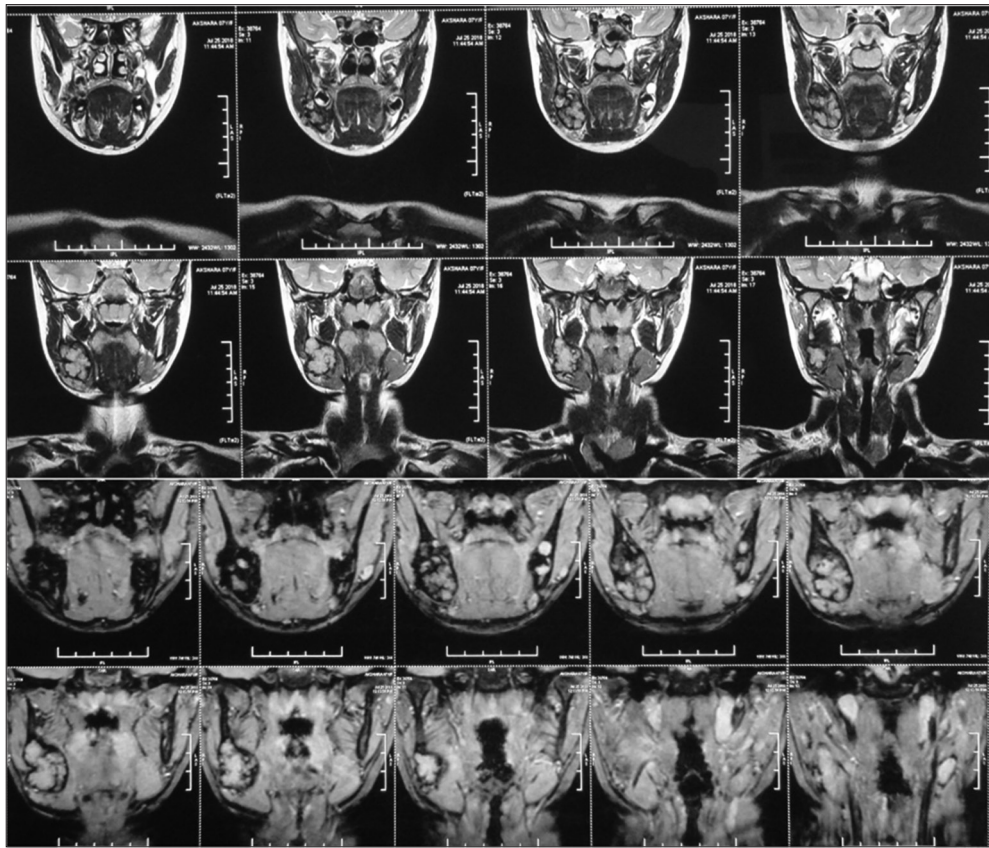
Magnetic resonance imaging of the lesion (coronal sections) revealing mild compression of the right submandibular gland by the expanding lesion of the right angle of the mandible
